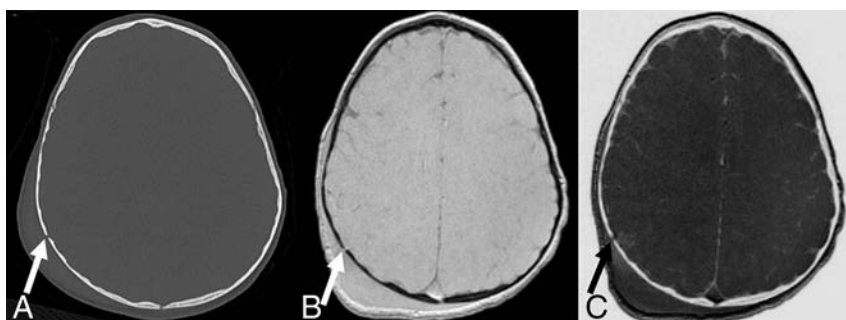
A, Axial CT image shows a nondisplaced linear fracture of the right parietal bone (arrow) with extracranial soft-tissue swelling. Black bone (B) and inverted black bone (C) MR images reveal equivalent visualization of the right parietal fracture (arrows), as well as overlying soft-tissue swelling.
